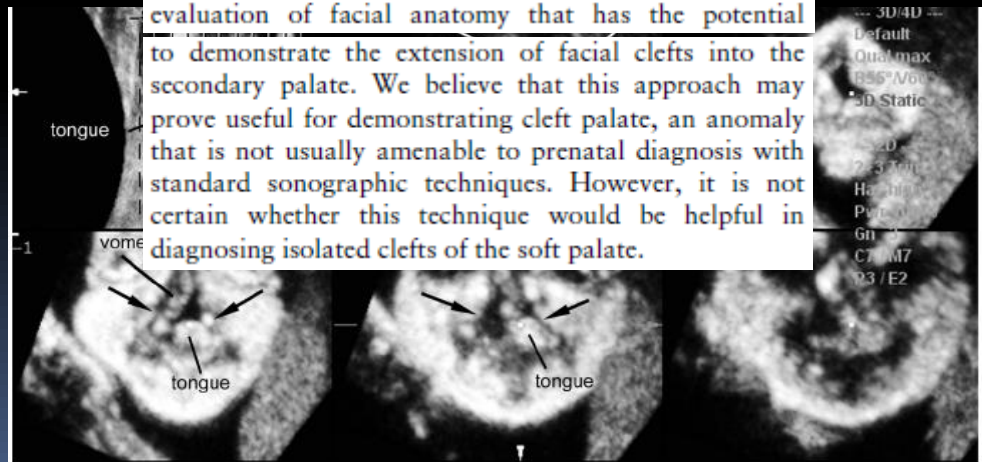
Tomographic ultrasound images in the coronal plane obtained from the same ultrasound volume as that in Figure 3. A comparison between the reference sagittal view and the coronal slices allows discrimination of the tongue from the surrounding tissues. The edges of the defect are well demonstrated (arrows).
